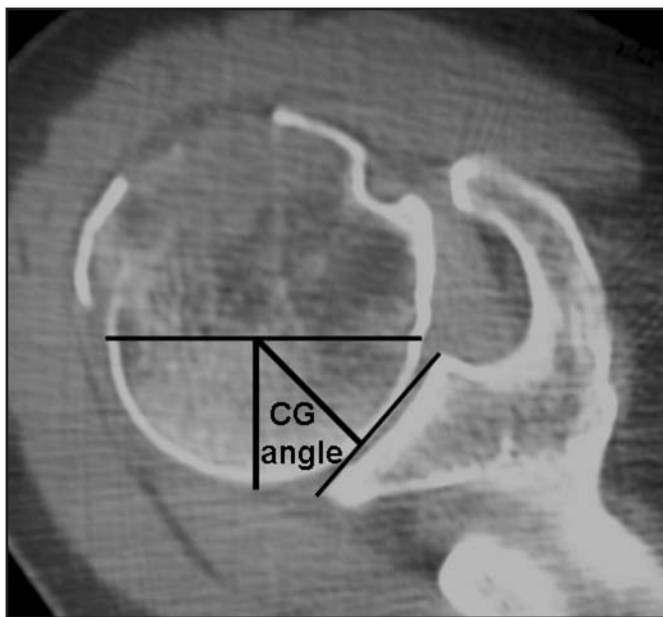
Humeral head orientation: cephaloglenoid angle. This angle is formed by the perpendicular line of the articular surface of the glena (in the horizontal plane), and the line resulting from joining the mean point of the diameter of humeral head semi-circumference with its articular surface apex (most prominent articular surface point). CT scan, axial view.
